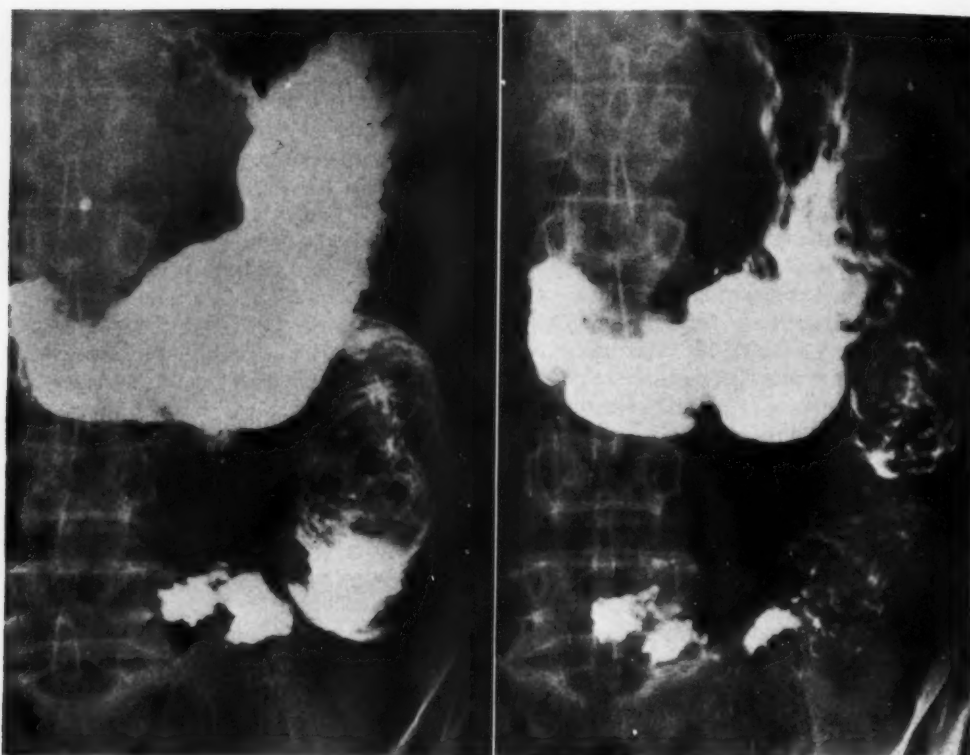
Roentgenogram obtained Sept. 1, 1949, showing dilated portion of the proximal jejunum with prominent plicae circulares and effacement of the normal feathery mucosal pattern.
